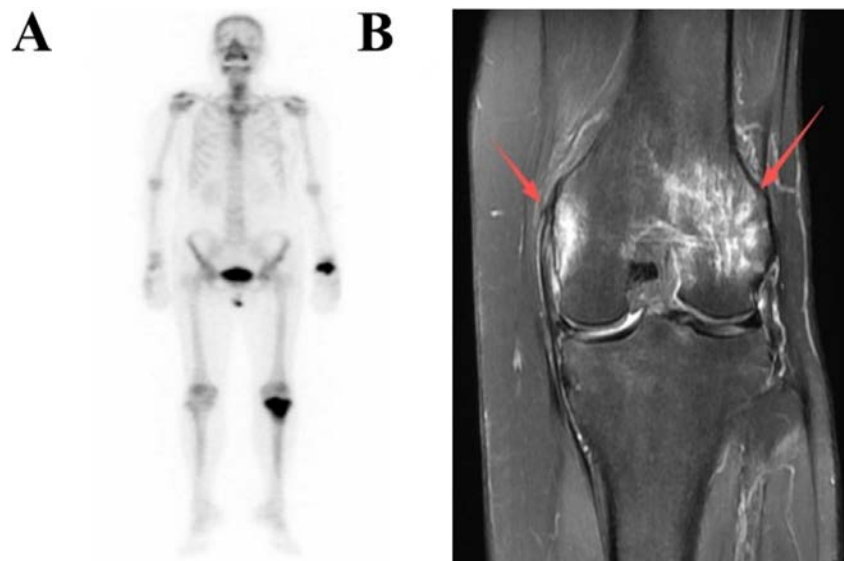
Imaging findings of the patient. (A) Whole-body bone scintigraphy with ^{99m}Tc-MDP showing increased radiotracer uptake in the left knee joint; (B) MRI demonstrating bone marrow edema in the distal left femur.
